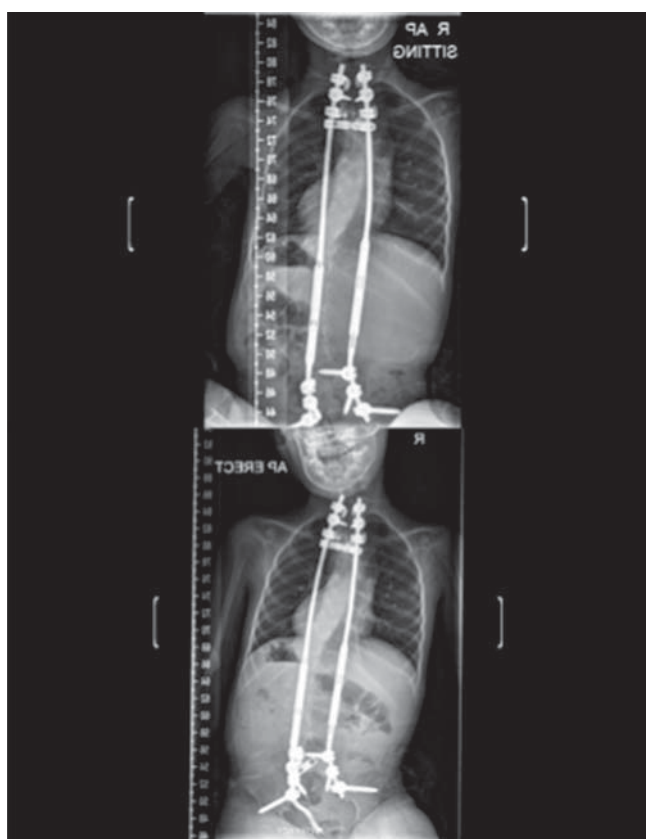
AP radiographs after third and fourth distractions (11 and 16 mo). AP indicates anteroposterior.
